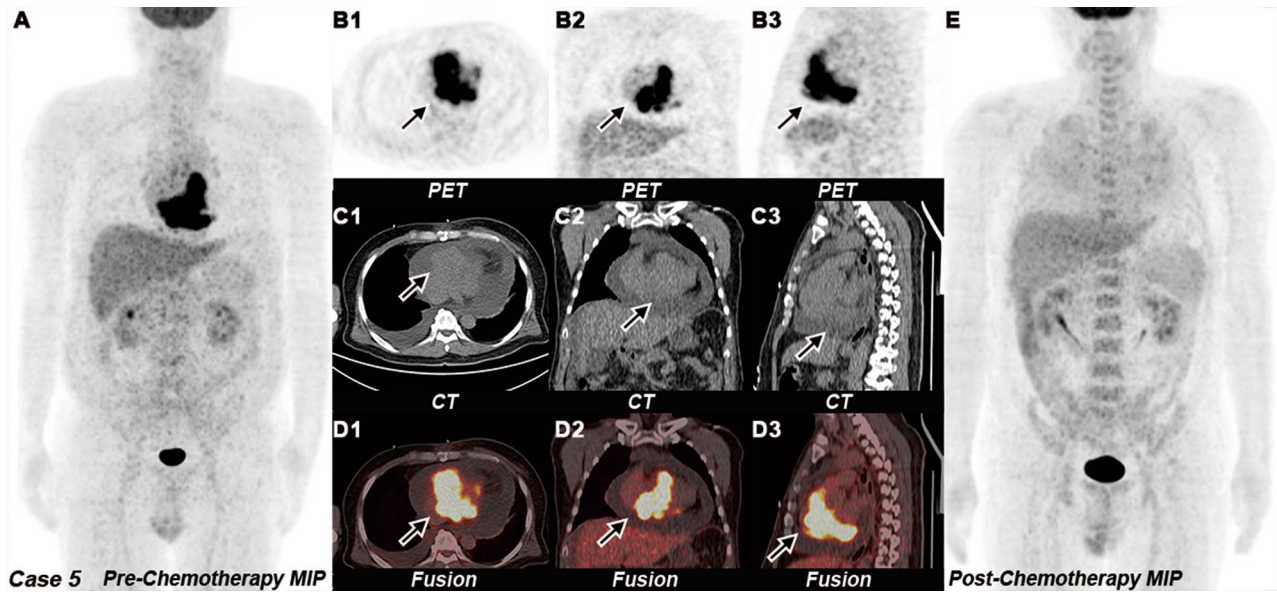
Primary cardiac lymphomas. MIP PET image before chemotherapy (A), ^{18}F -FDG PET (B), CT (C), fusion images (D), and MIP PET image after chemotherapy (E). Transverse (1), coronal (2), and sagittal images (3). A MIP image showing foci of uptake in the heart region before chemotherapy. B, C, and D showing a huge irregular mass with increased intense ^{18}F -FDG uptake (SUVmax: 18.3) in the atrioventricular groove (arrows). E MIP image showing an absence of clearly pathologic ^{18}F -FDG uptake in the heart region after chemotherapy, mild uptake in the bilateral lung region, and pulmonary inflammation confirmed by CT..
